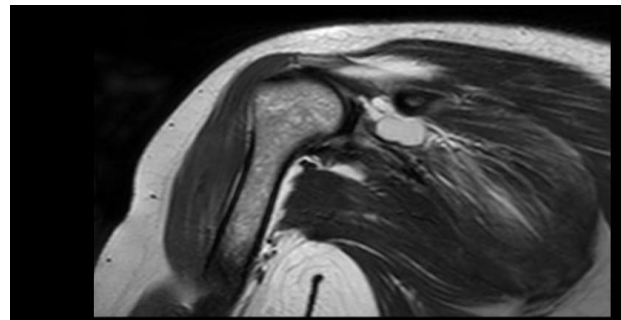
An image of MRI of a female patient suggesting presence of spinoglenoid notch ganglionic cyst (arrow).
